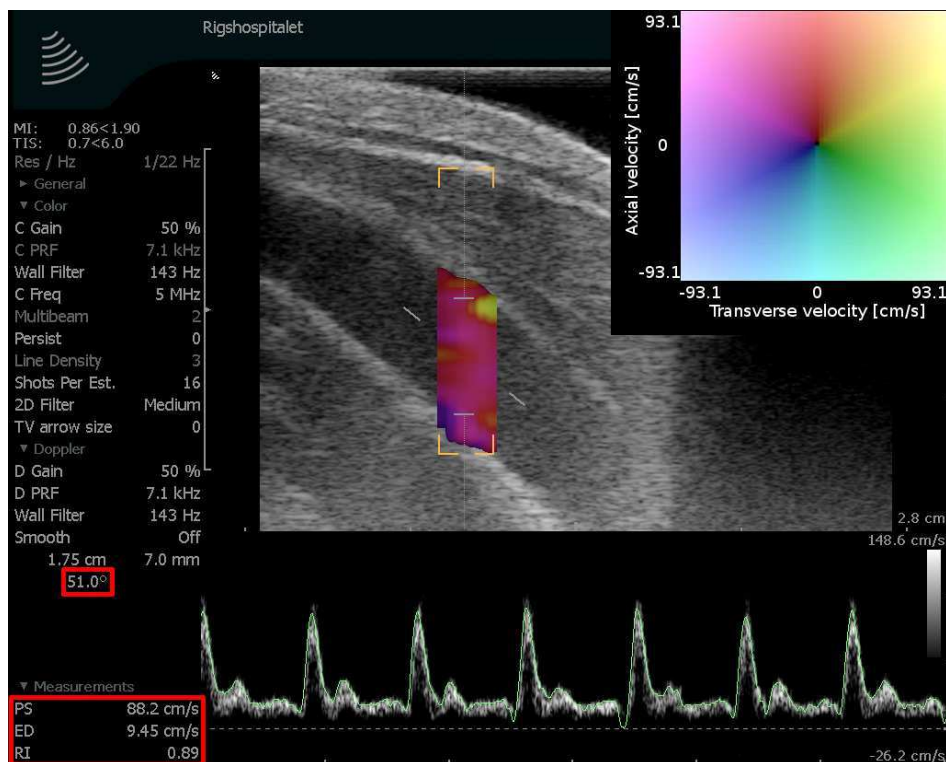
Ultrasound image frame showing the longitudinal ultrasound scanning of the right common carotid artery with interleaved spectral velocity estimation and vector flow.*
